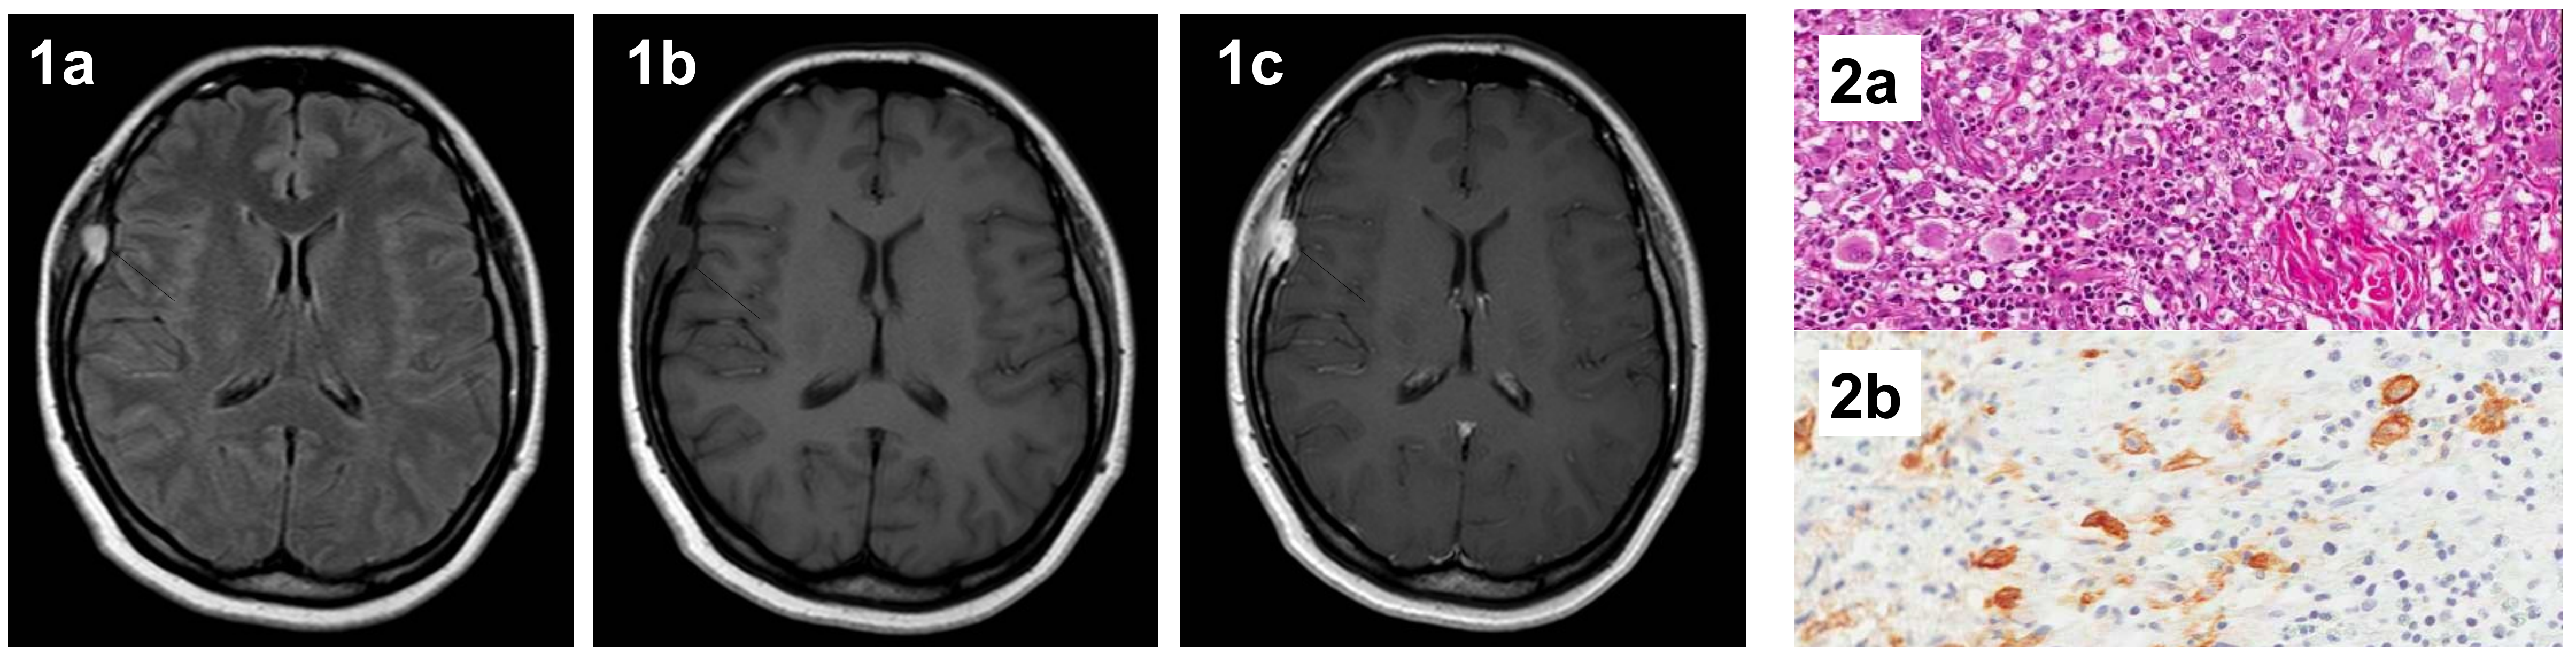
MRI showing a small intradiploic lesion of the skull in the right frontotemporal region with initial subgaleal soft tissue involvement (red arrow). Signal analysis of the lesion revealed FLAIR hyperintensity (1a) and T1 isointensity (1b) with important contrast enhancement after gadolinium infusion (1c).
